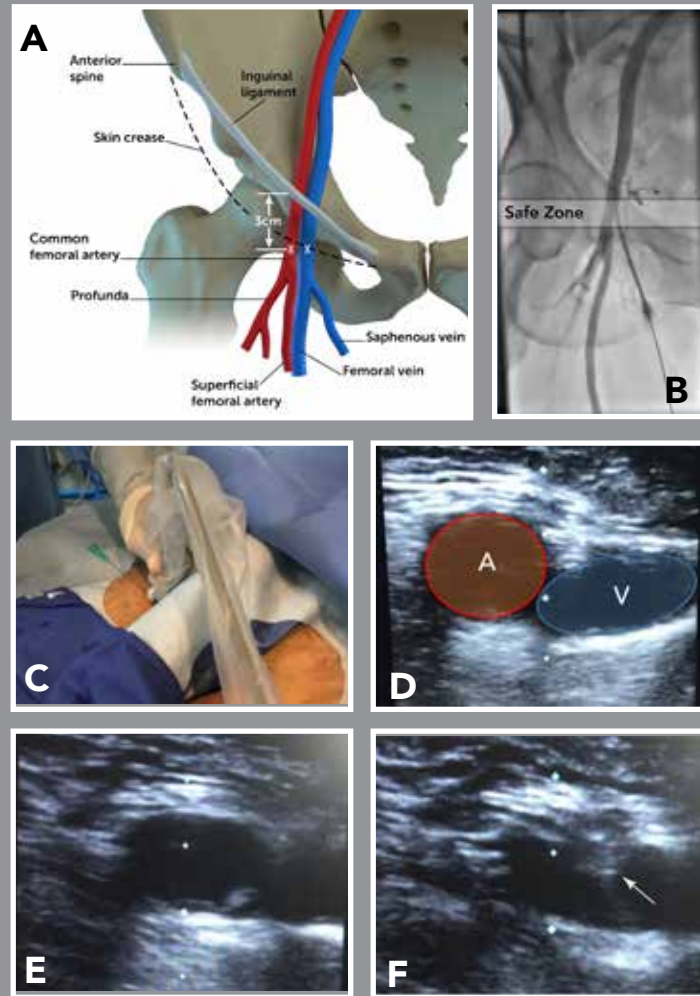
Contemporary Femoral Access Technique With Utilization of Ultrasound and Fluoroscopy
